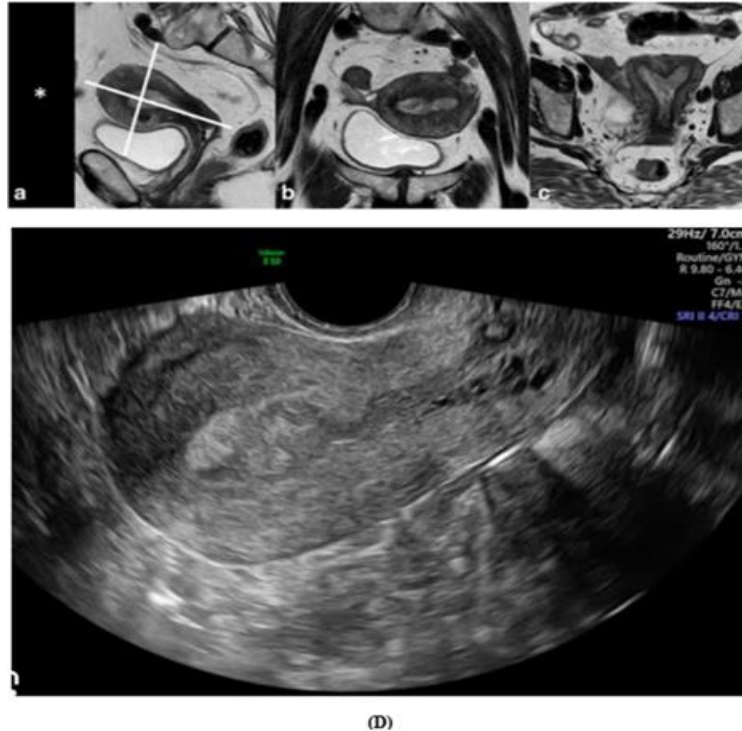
T2W images (A) sagittal, (B) axial, Post contrast T1 fat suppressed images (C) axial, (D) sagittal, DW images (E) axial, (G) sagittal, ADC map (F) axial, (H) sagittal, TVUS (I) TVUS: trans-vaginal ultrasound
